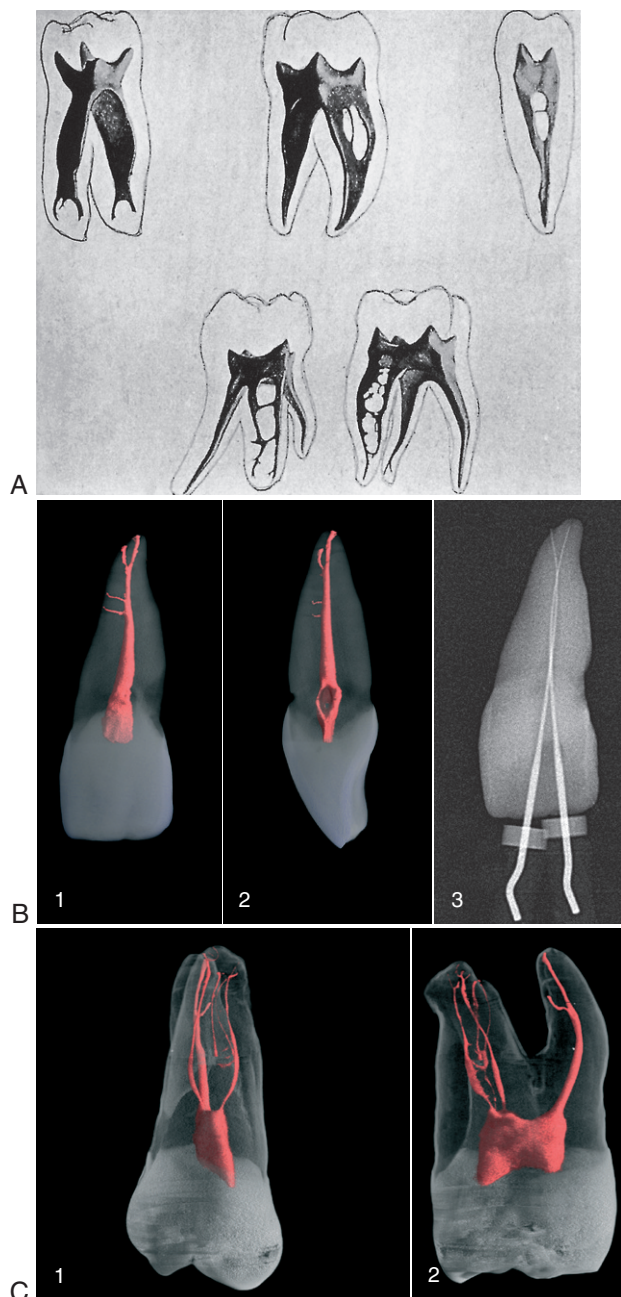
A, Molar and bicuspid pulp cavities. Note the prominence of the pulp horns and the complexities of the pulp chambers and root canal systems. B, Microcomputed tomographic scans of dental anatomy (36 µm resolution). 1, Clinical view of tooth #9 shows two accessory canals and an apical bifurcation. 2, Mesiodistal view of the tooth shown in 1. 3, Working length radiograph with files placed in both apical canal aspects. C, Microcomputed tomographic scans of more complicated dental anatomy (36 µm resolution). 1, Clinical view of tooth #3 shows a fine mesiobuccal and distobuccal canal system with additional anatomy in all three roots. 2, Mesiodistal view of the tooth shown in 1. (A from Riethmuller RH: The filling of root canals with Prinz' paraffin compound, *Dent Cosmos* 56:490, 1914. B and C from Cohen S, Hargreaves KM: *Pathways of the pulp*, ed 9, St Louis, 2006, Mosby.)
